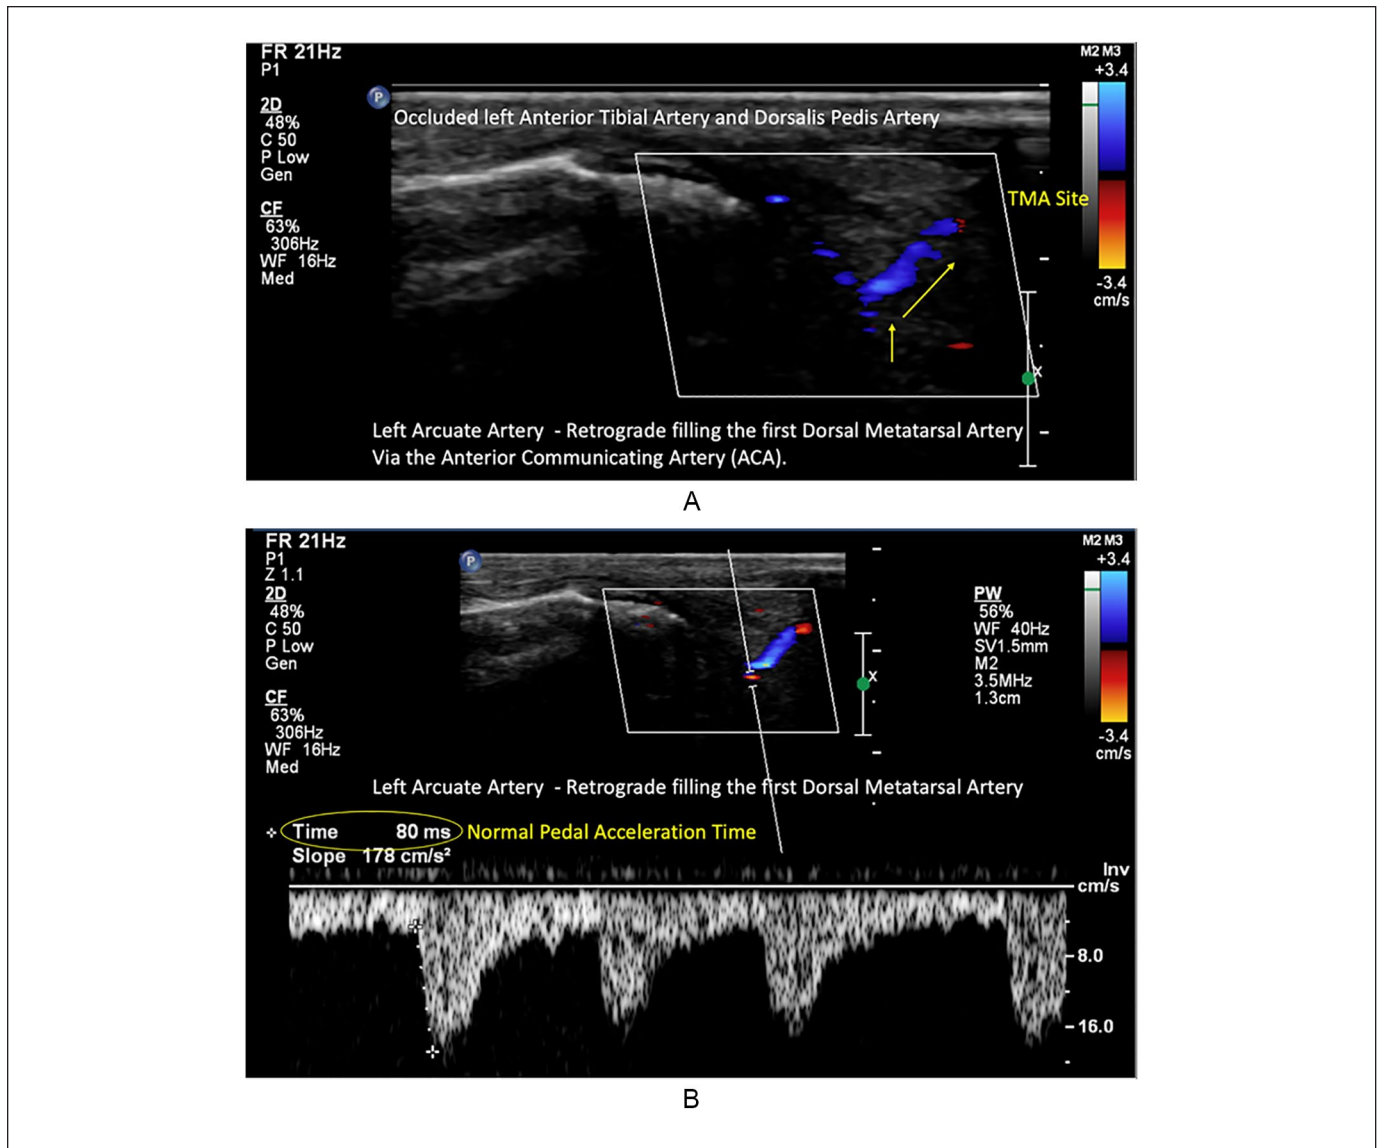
(A) Color doppler indicating retrograde flow in the arcuate artery; (B) spectral doppler indicating retrograde flow in the arcuate artery via the deep plantar artery (plantar circulation).
